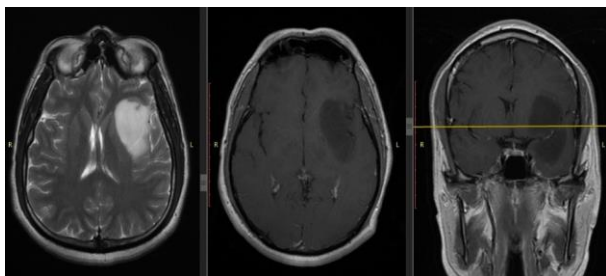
MRI (a)T2WI axial, (b) and (c) T1 axial and coronal post contrast images showing abnormal signal intensity lesion in the left inferior frontal and anterior temporal lobes appearing hyperintense on T2W without significant post contrast enhancement.
